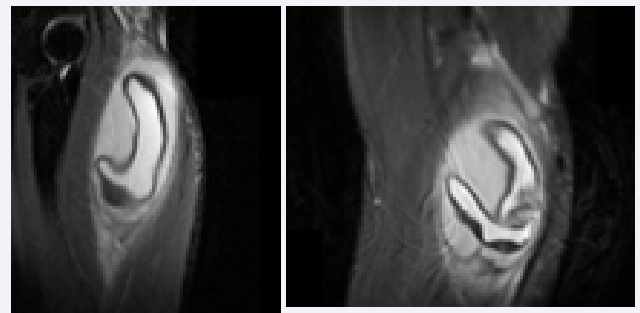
MRI show hydatid cyst of brachioradialis muscle.
